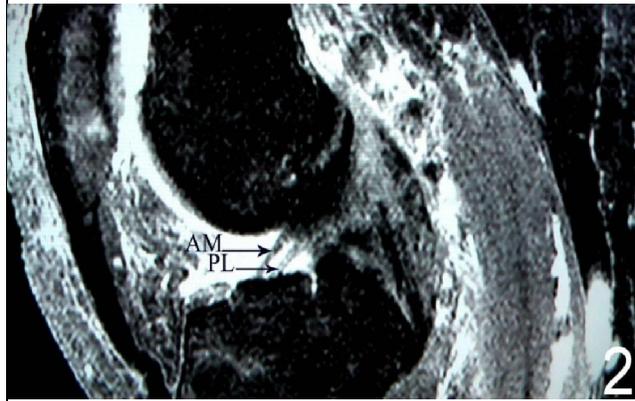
MRI of Knee joint showing the anteromedial (AM) and posterolateral (PL) bundles of the anterior cruciate ligament
